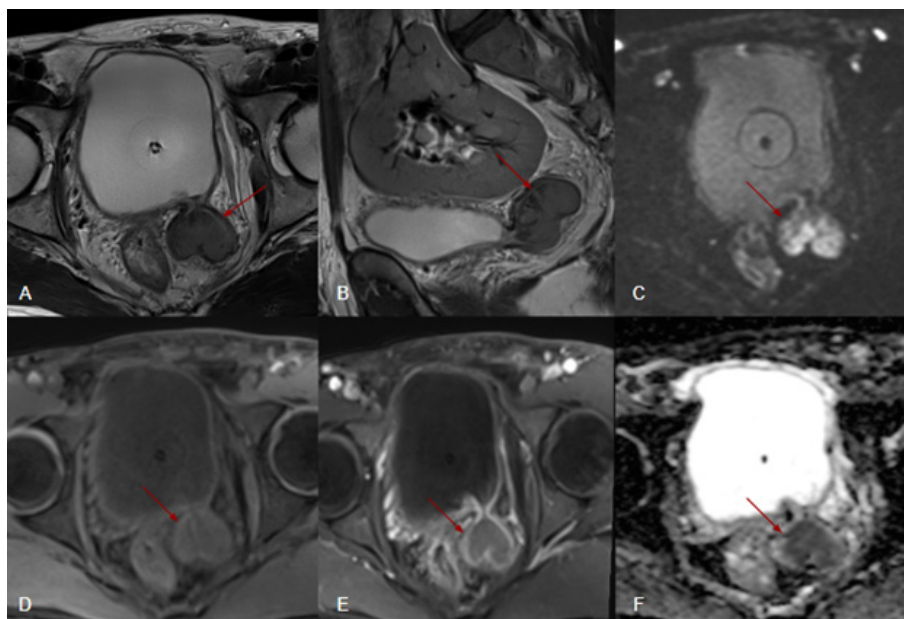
Pelvic MRI axial (A - T2-weighted, C - Diffusion-weighted, D - T1-weighted without contrast, E - T1-weighted venous phase, F - ADC map) and sagittal (B - T2-weighted) images showing a solid lesion located within a bladder diverticulum adjacent to the left ureterovesical junction (red arrows). This lesion is hypointense on T2-weighted images (A and B), exhibits restricted diffusion (C and F) and enhances after contrast administration (E). The wall of the diverticulum appears mildly thickened but intact, with no visible infiltration of the perivesical fat. No invasion of the neck of the diverticulum or adjacent bladder wall are seen.
